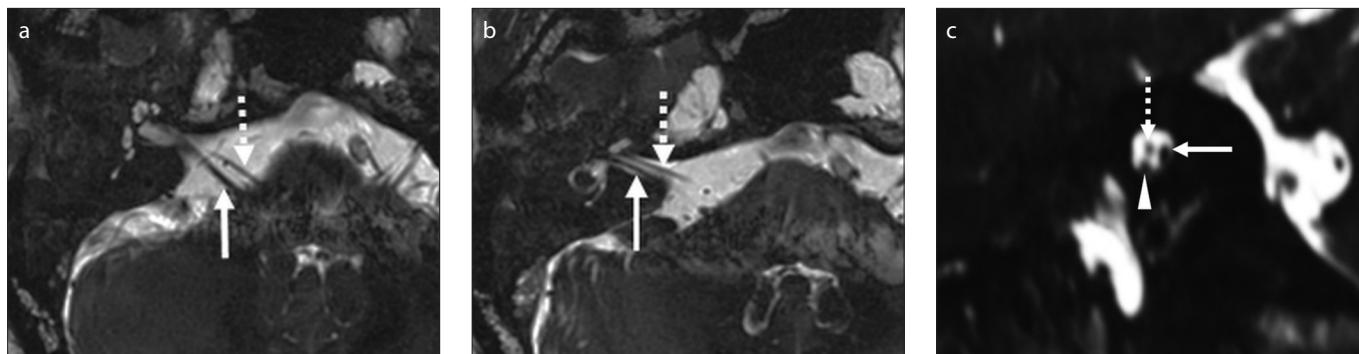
a–c. Anatomy of the right facial nerve (FN) on axial (a, b) and sagittal (c) high-resolution heavily T2-weighted images. The cerebellopontine cistern (CPC) segment of FN (a, dotted arrow) is related to the vestibulocochlear nerve posteriorly (a, arrow). The internal acoustic canal (IAC) segment of FN (b and c, dotted arrow) is related to the cochlear nerve inferiorly (c, arrowhead) and the superior vestibular nerve posteriorly (b and c, arrow).
